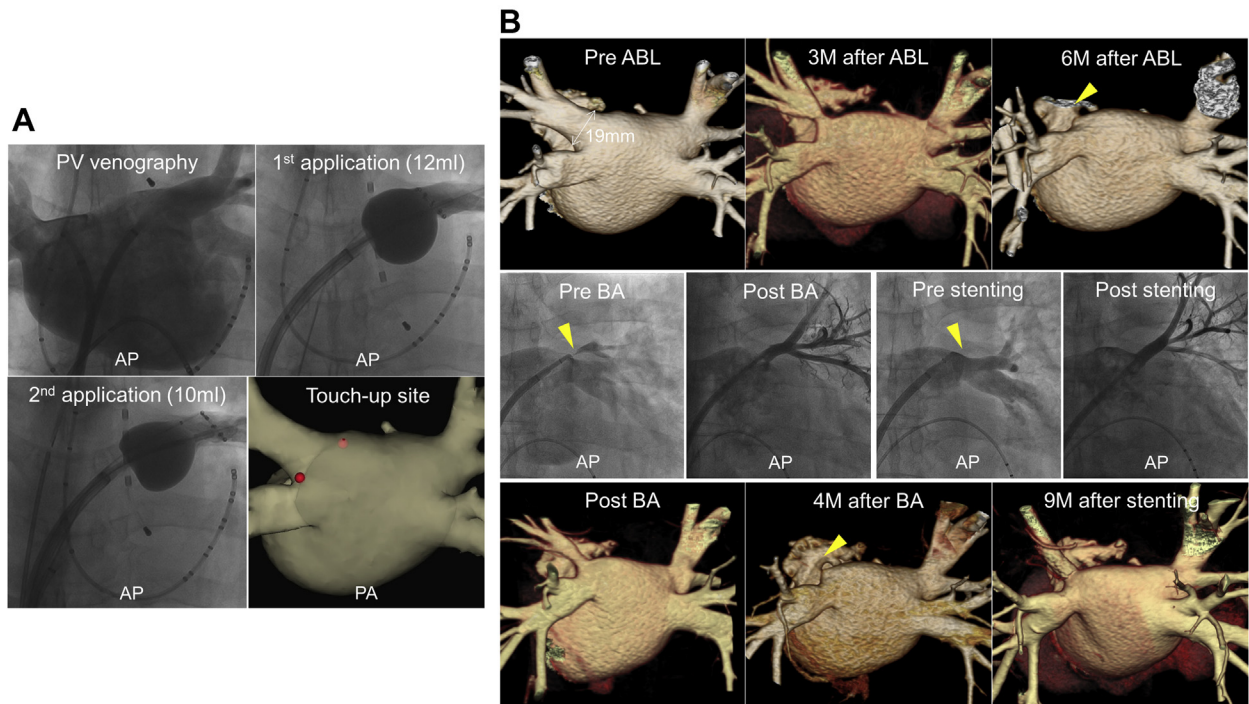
A: Position of hot balloon applications and touch-up ablation sites in LSPV. B: Computed tomography and angiography pre and post LSPV angioplasty. ABL = ablation; AP = anterior-posterior view; BA = balloon angioplasty; PA = posterior-anterior view; PV = pulmonary vein.
